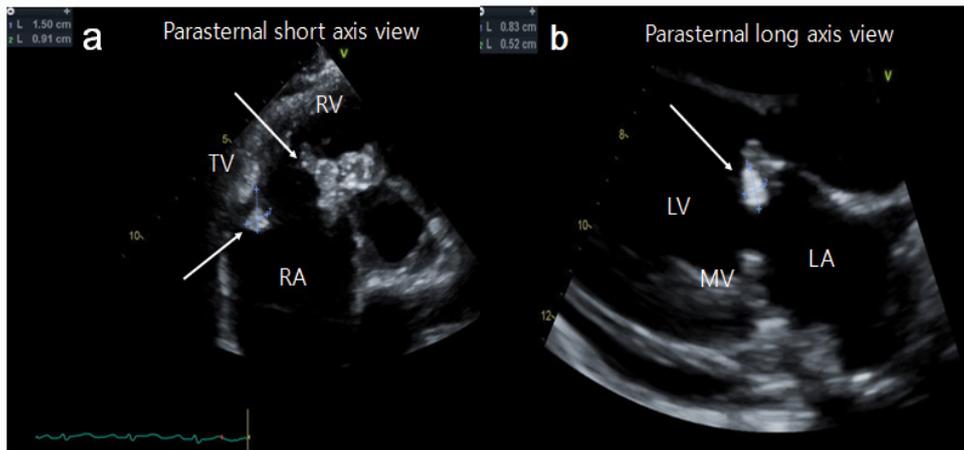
Transthoracic echocardiography showing multiple vegetation. Arrows indicate multiple vegetation on tricuspid valve annulus (a) and mitral valve annulus (b) MV: Mitral Valve; LA: Left Atrium; LV: Left Ventricle; RA: Right Atrium; RV: Right Ventricle; TV: Tricuspid Valve
